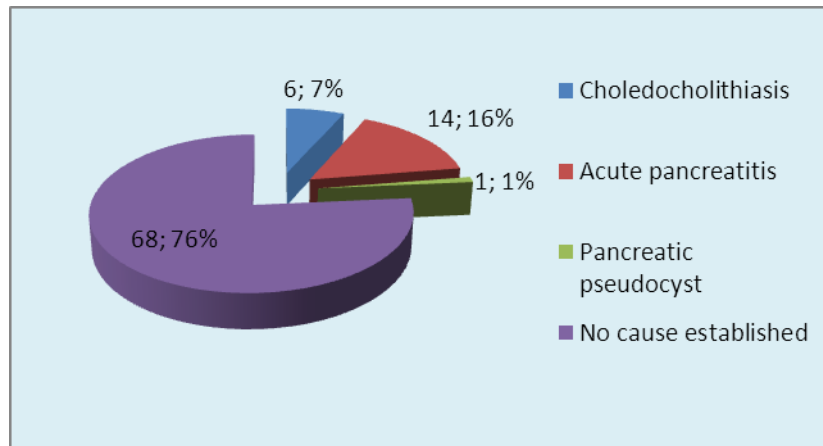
№8 Ultrasound findings in intrapancreatic/ampullary area (n=89)
